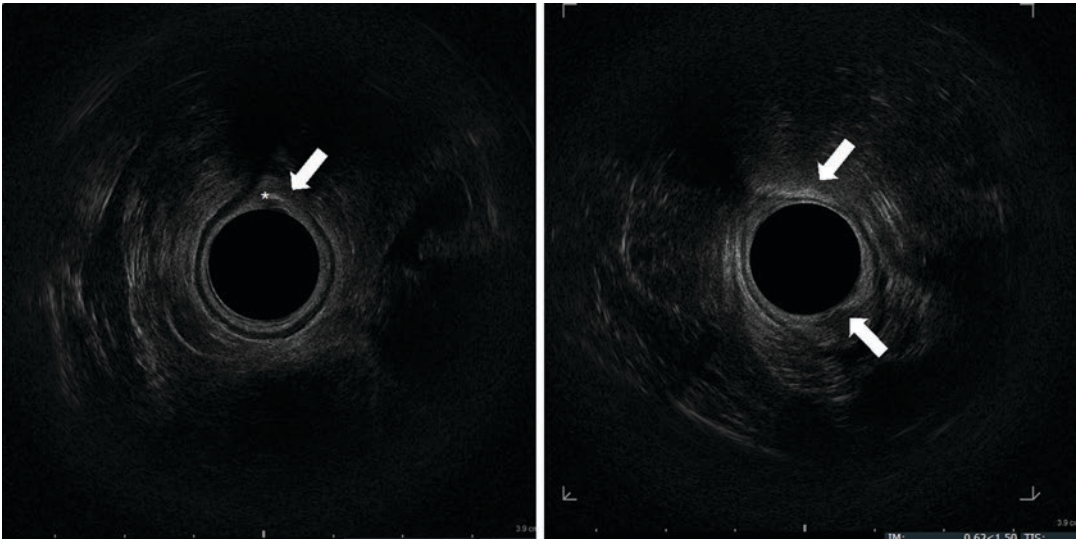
Endosonographic axial sections of the middle anal canal. Asterisk: needle in the internal anal sphincter; arrow: injected fat tissue h 6 and 12
